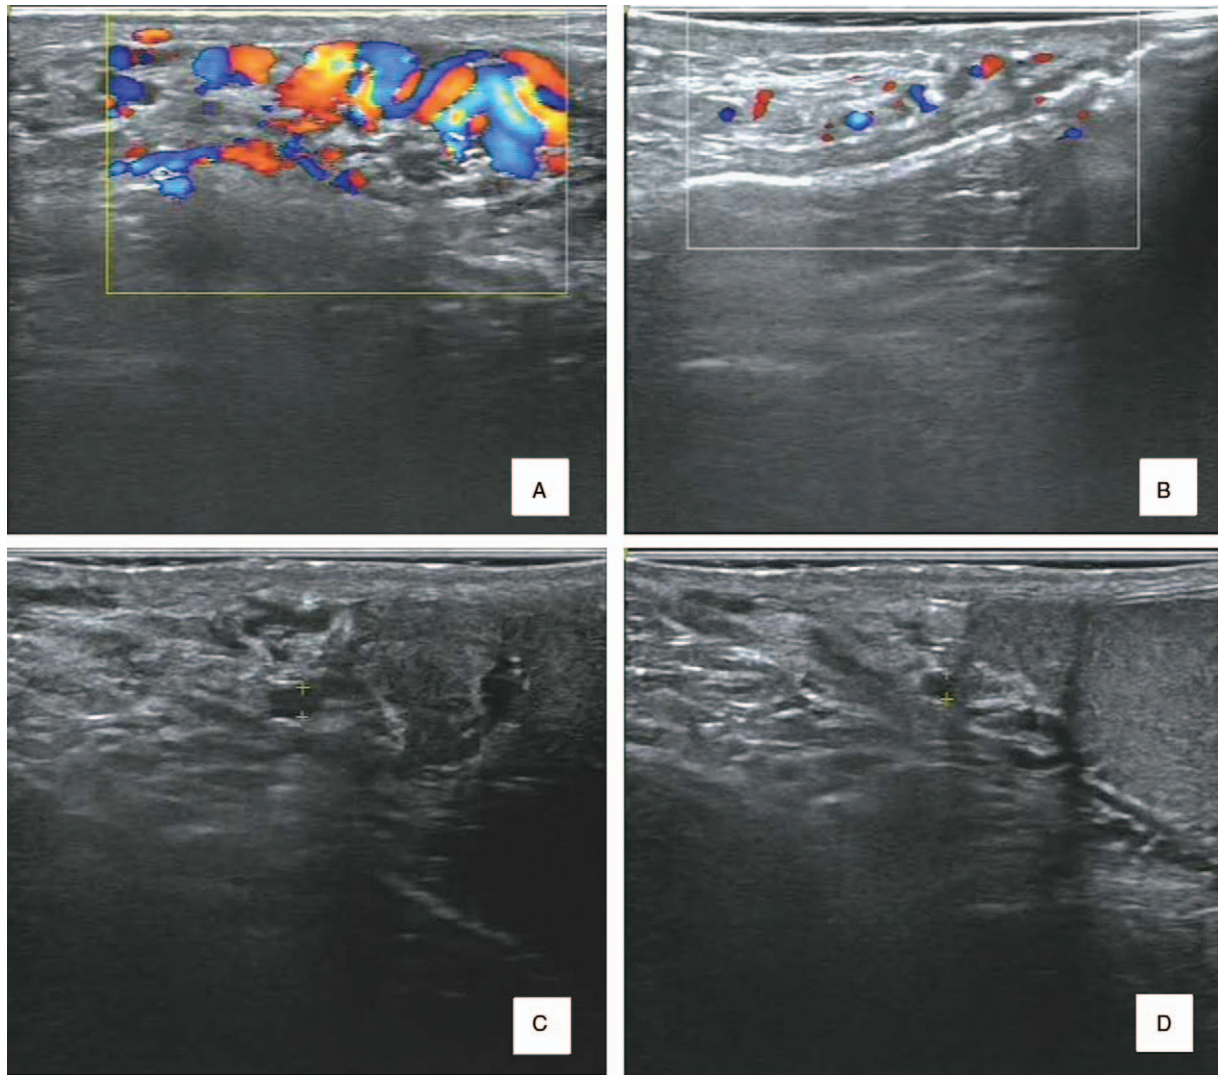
Ultrasound (A), before treatment, revealed that the pampiniform plexus was significantly decreased, and flow was only seen with Valsalva maneuver. Ultrasound (B), after treatment, revealed that anastomotic blood flow rates were unobstructed, and no narrow or thrombotic parts were observed. Ultrasound (C) shows that the diameter was wide before treatment, with a maximum diameter of 2.8 mm. Ultrasound (D) shows that the maximum diameter of the spermatic vein had decreased to 2.2 mm.
